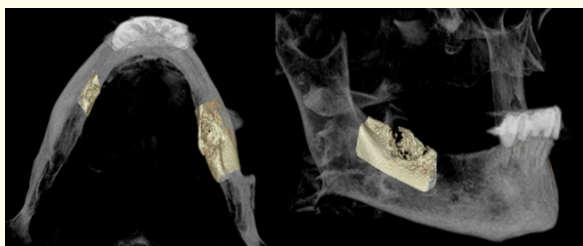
3D - CBCT - Reconstruction images of the patient.
